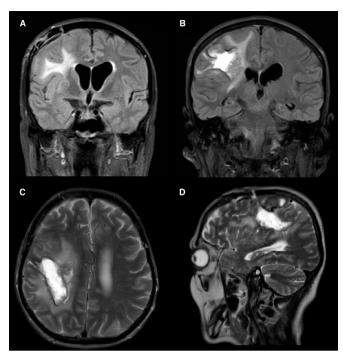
Postsurgery MRI analysis. MRI performed 1 month after hospital admission, showing residual gliosis around the evacuated right-sided frontoparietal haemorrhage (A and B: coronal view of fluid-attenuated inversion recovery imaging; C: axial T2 imaging and D: sagittal T2 imaging). The finger-shaped morphology is unusual.
